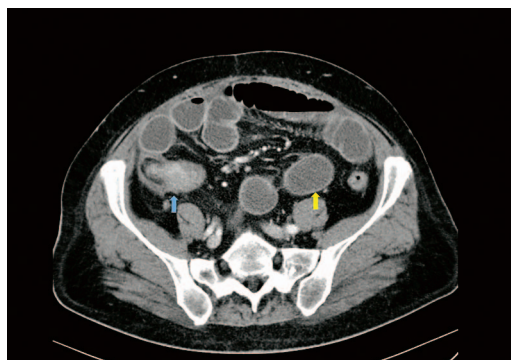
CT of the abdomen and pelvis, performed with contrast
